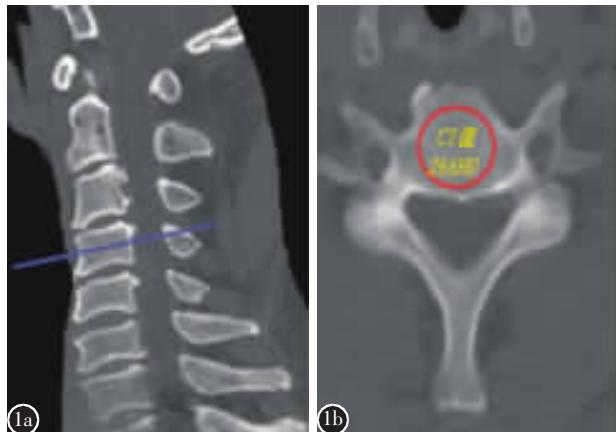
颈椎椎体 CT 值测量 a 在颈椎 CT 矢状面重建图片上进行定位 b 在中横断面上测量 CT 值
